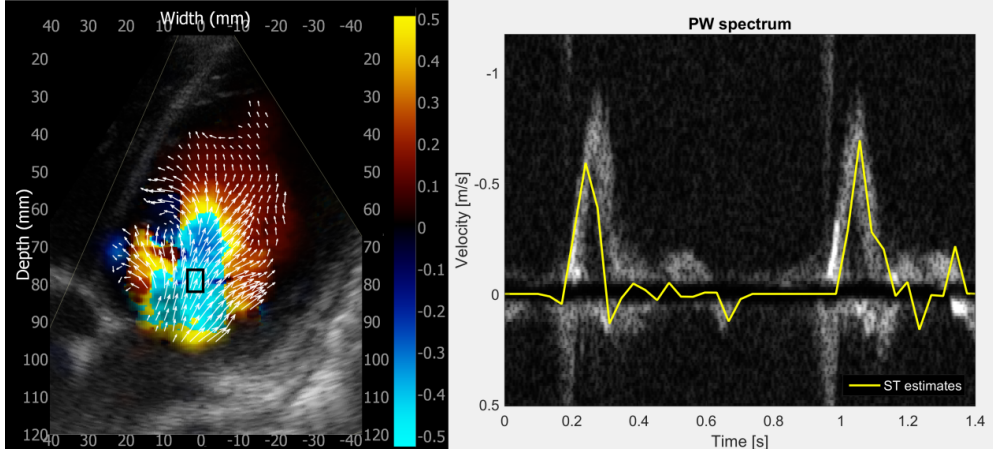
Validation of speckle tracking (ST) estimates. Left: Vector flow map overlaid color flow image of the left ventricle of patient 2 (dilated cardiomyopathy). Right: Pulsed-wave (PW) Doppler spectrum acquired from a separate recording. The yellow line represents the ST velocity trace from a corresponding ROI (black square in the left image). The ST velocities have been projected on to the PW acquisition beam for comparison.
